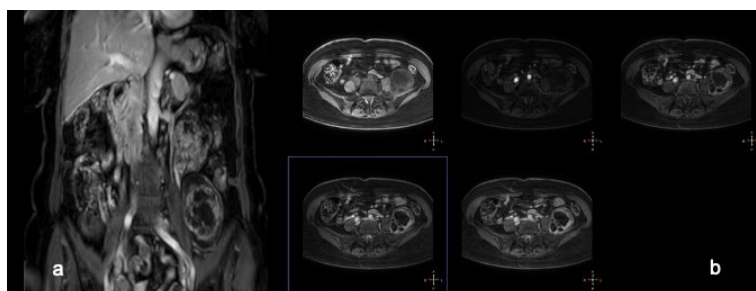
Portal venous coronal (a) and dynamic contrast enhanced (DCE) axial MR images (b)
